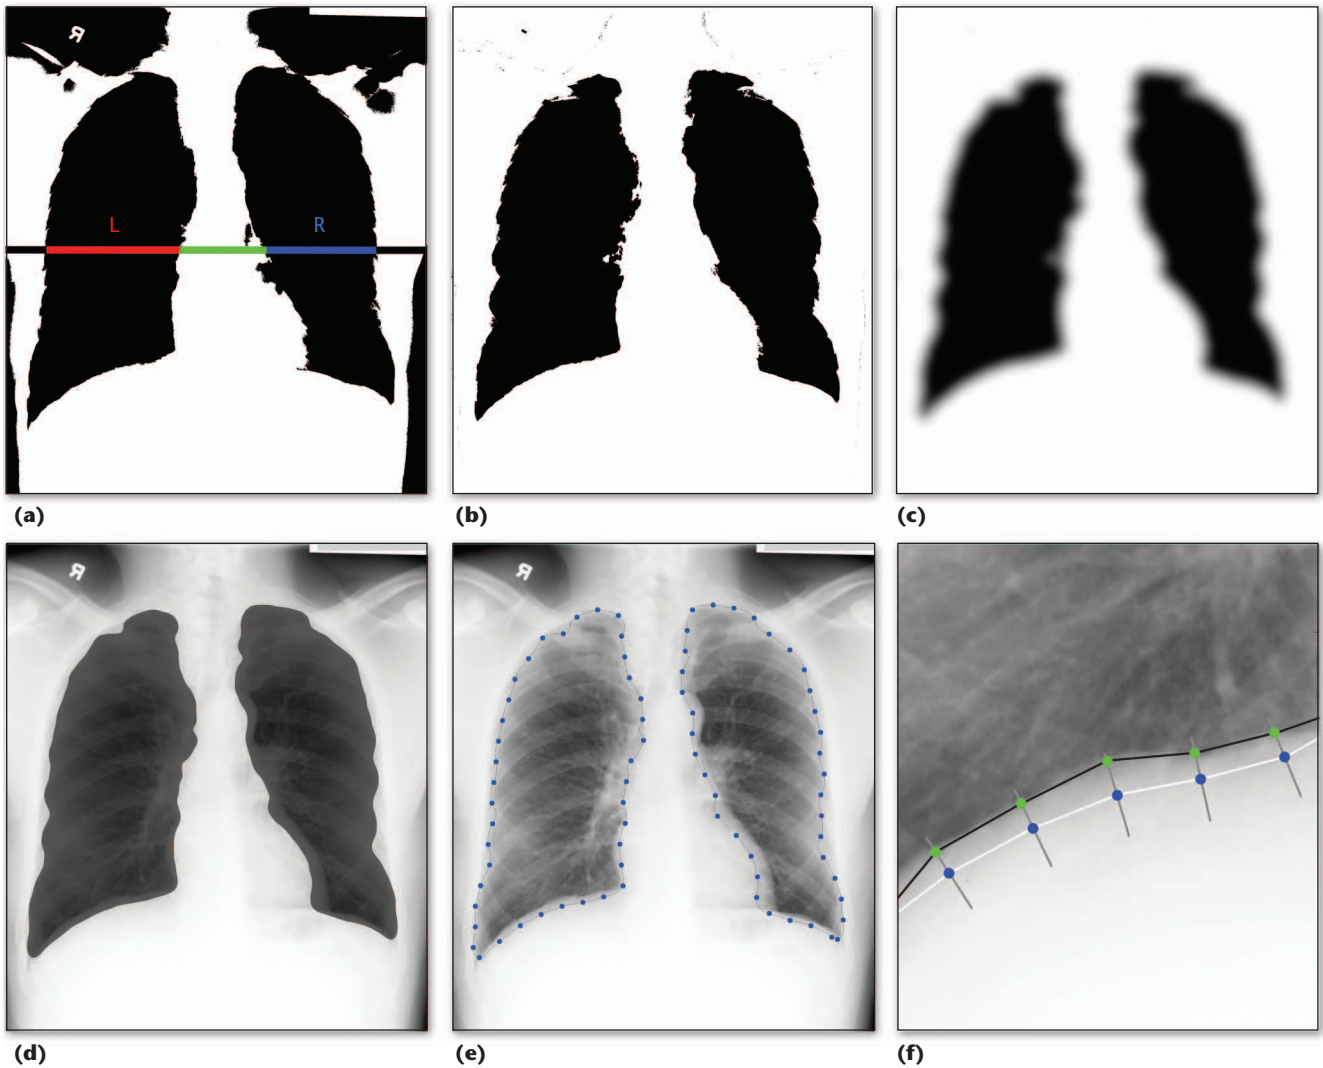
Lung segmentation: (a) lung patches found after initial thresholding, (b) removal of black around the image border, (c) Gaussian smoothing to remove noise, (d) the initial lung segmentation, (e) the segmentation discretized into a series of vertices, and (f) the lower vertices refined on the basis of the maximum intensity change. The green points represent the new segmentation border. The horizontal line in (a) depicts one scan line, with the segmented areas marked in different colors. All the steps depicted are essential to achieving an accurate segmentation of the lung field in the PA x-ray image.
